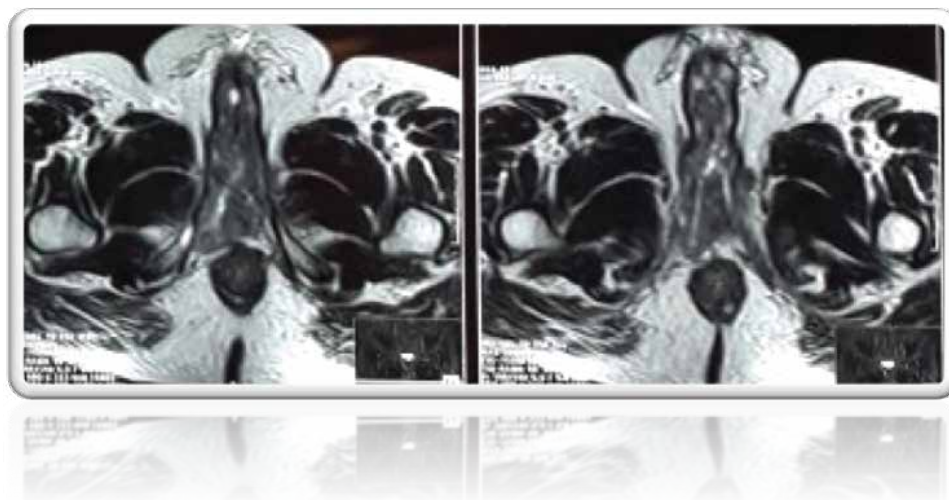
1 MRI showing diffuse thickening of penile shaft.
